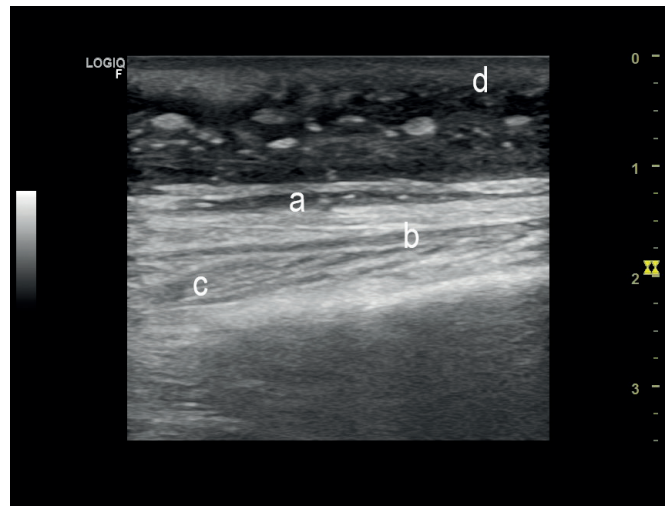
Ultrasonographic sign of the advanced stage of necrotizing fasciitis.
